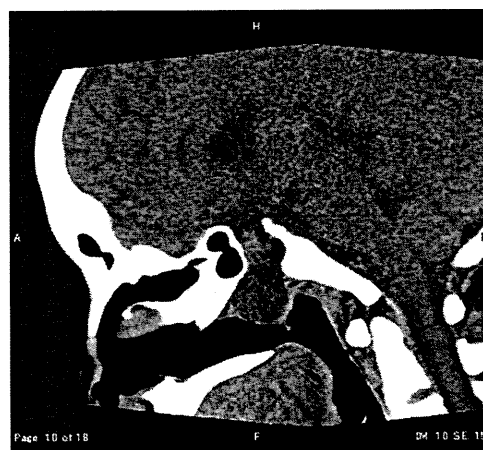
Sagittal head CT demonstrated a bone defect in the floor of the sella turcica by a transsphenoidal soft tissue mass extending into the epipharynx.
